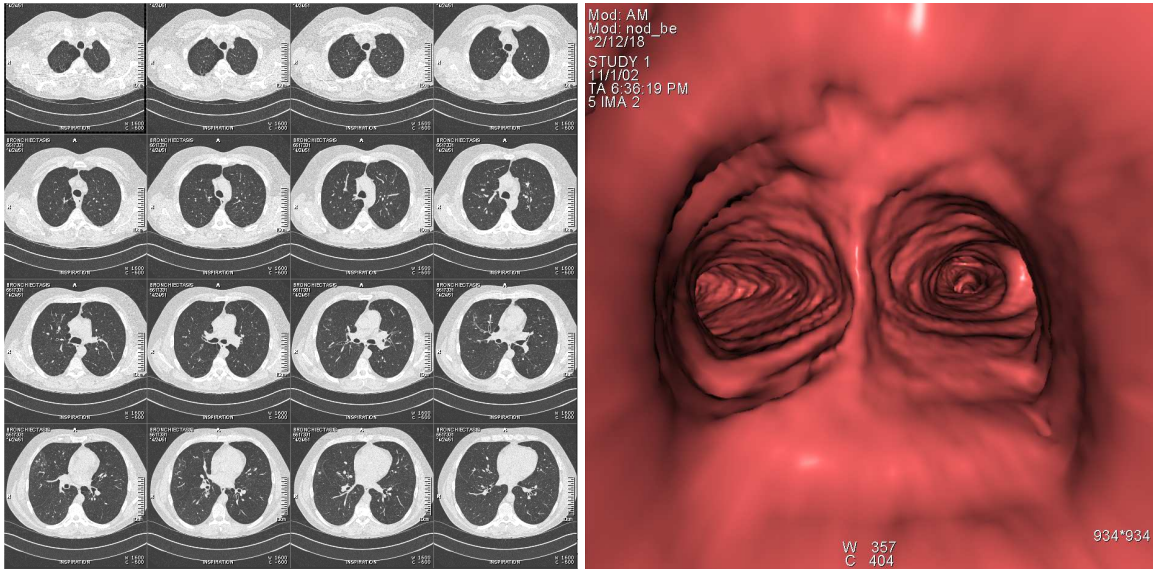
Chest CT scan of a 84 year old male patient. Left: 16 (out of 300) single axial cross sections. Right: Virtual endoscopic view (perspective volume rendering) from inside the lung, showing the main carina (bifurcation). *Courtesy: Siemens Corp. Research (SCR)*
